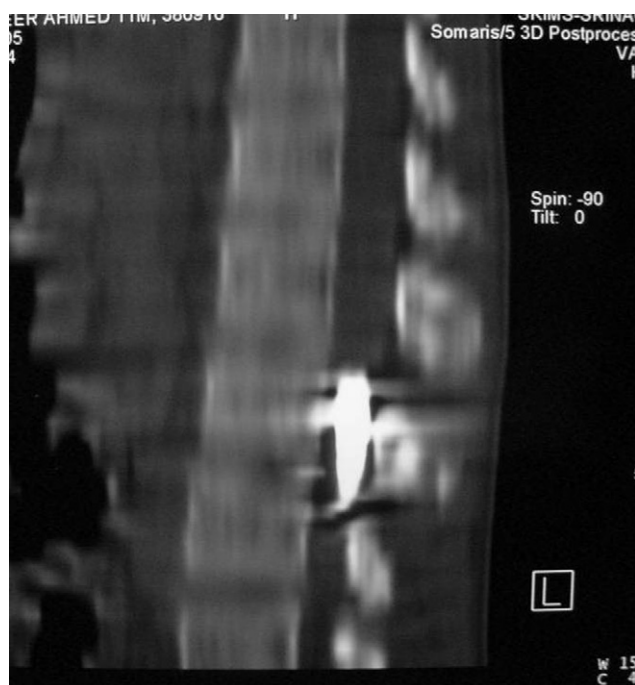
CT-scan sagittal reconstruction shows, Second-Flight of a Bullet, a metallic-bullet of 3° mm long × 10 mm dia. in the process of migration inside lower dorsal spinal canal (See Fig. 9).
